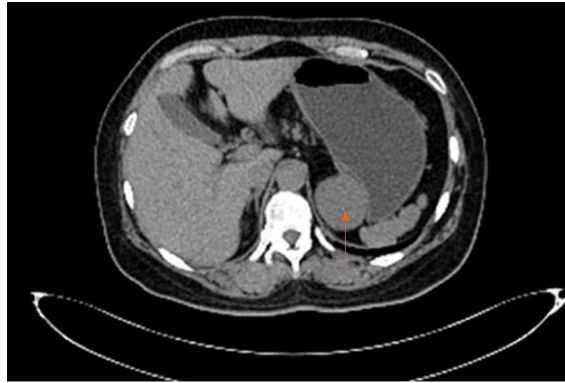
Imaging at admission. A plain computed tomography scan demonstrated a 52 mm × 43 mm quasi-circular mass (arrow). It appeared to have a low density of 29 HU and was closely related to the lesser curvature of the gastric fundus, which also showed an extraluminal growth pattern with an obvious border.
